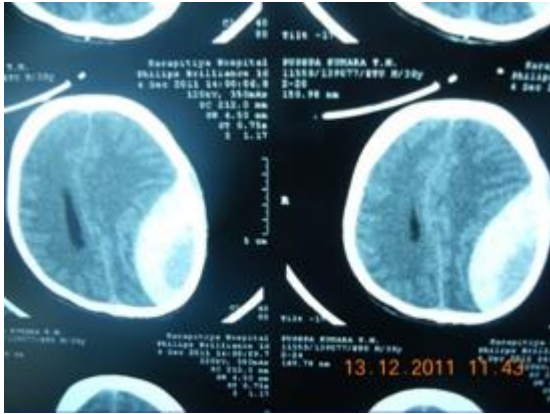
Left parieto-occipital extra dural haemorrhage (CT scan image)
